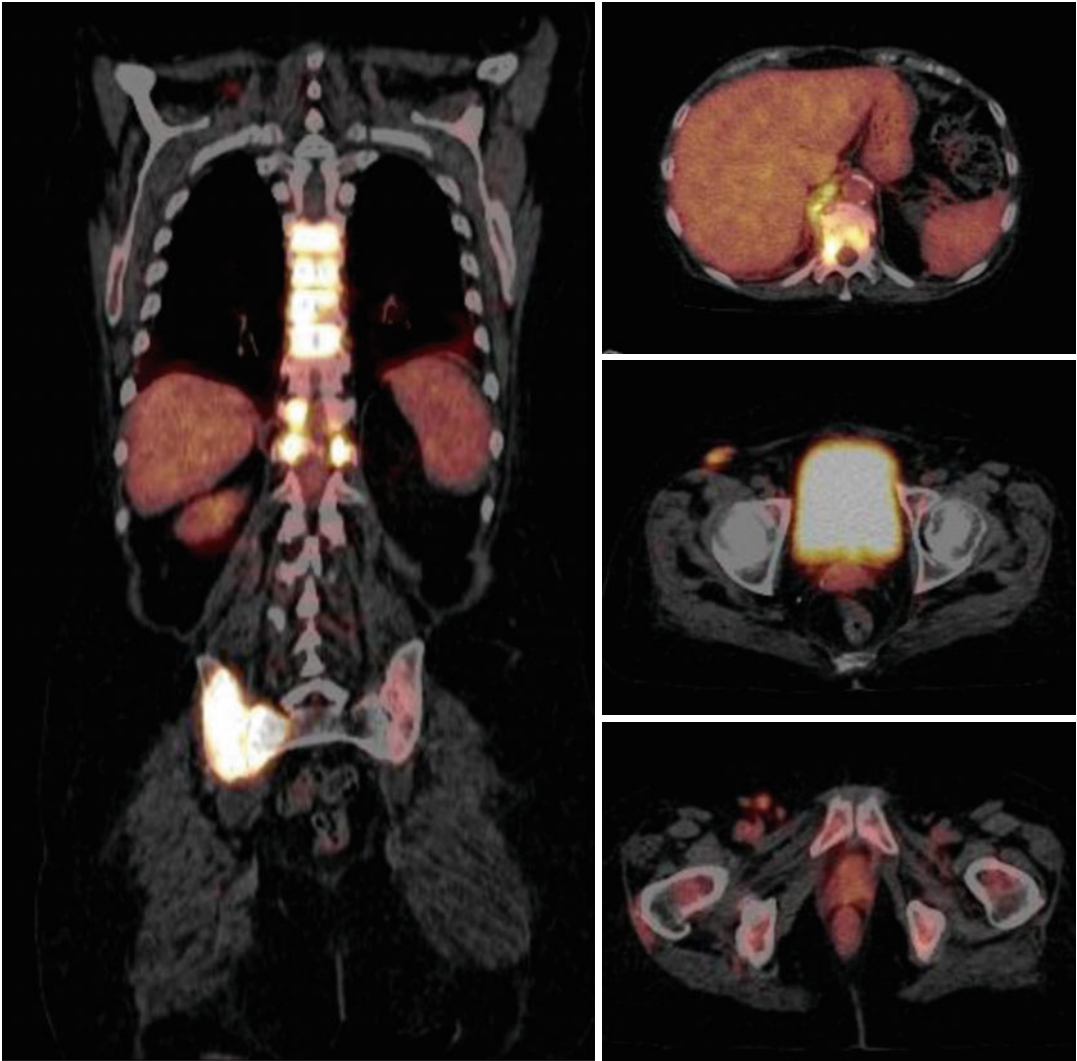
FDG PET/CT – baseline: Increased metabolic activity in multiple lymph nodes (*right panel*), and in multiple vertebrae of the thoracic and lumbar spine as well as the right iliac bone and sacrum (*left panel*)
